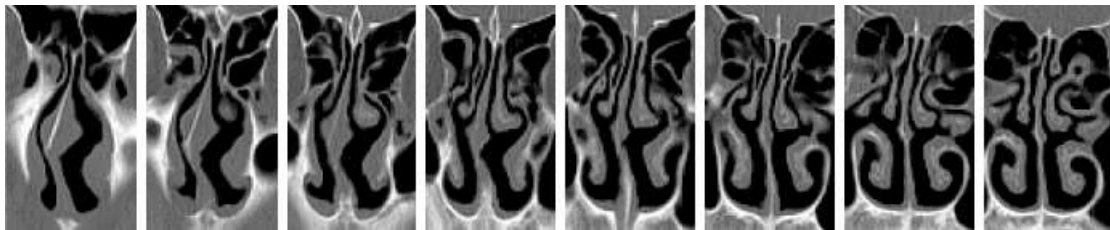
The continuous coronal CT image of nasal septum deviation.
